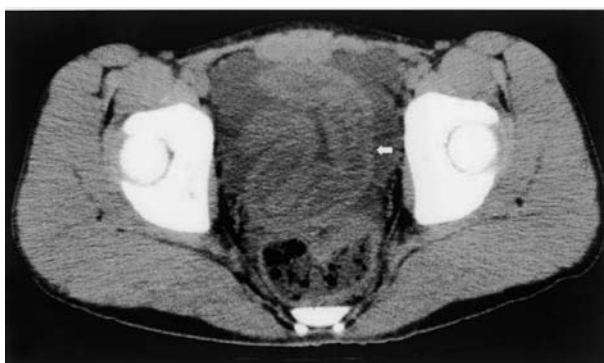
Abdominal computed tomography revealed moderate quantities of ascites and wall thickness of intestine (arrow).
